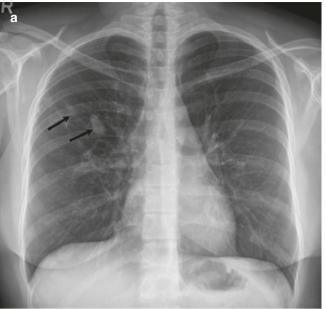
A 57-year-old asymptomatic woman with congenital bronchial atresia of the anterior segment of the right upper lobe. (a) Frontal chest radiograph shows tubular opacities (arrows) in right upper lobe with "finger in glove" appearance. (b–d) Axial CT images show hyperlucent, hyperexpanded anterior segment of the right upper lobe (asterisk) with central bronchoceles (arrows)
